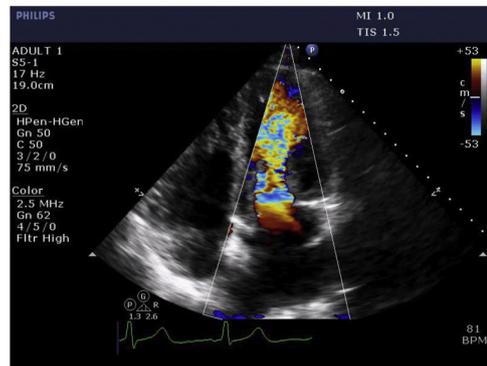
Color Doppler in apical 4-chamber view on transthoracic echocardiography displaying increased forward blood flow through the mitral valve during diastole, indicating mitral inflow obstruction caused by the mass.
